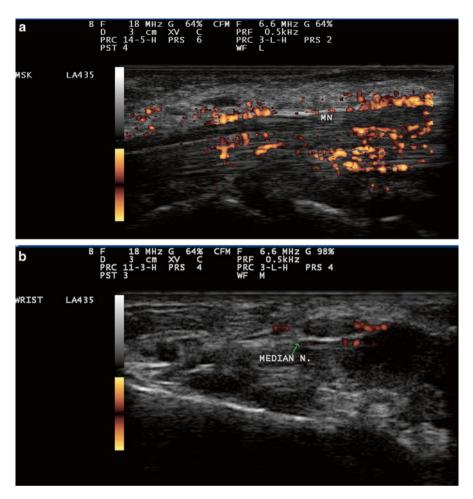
Power Doppler ultrasound scan of the wrist in a patient presenting with carpal tunnel syndrome symptoms using Esaote Mylab 25 system. (a) Palmar longitudinal view at the proximal inlet of the carpal tunnel showing perineurial enhanced vascularity of the median nerve. (b) Palmar transverse view at the proximal inlet of the carpal tunnel showing perineurial enhanced vascularity of the median nerve secondary to tenosynovitis
